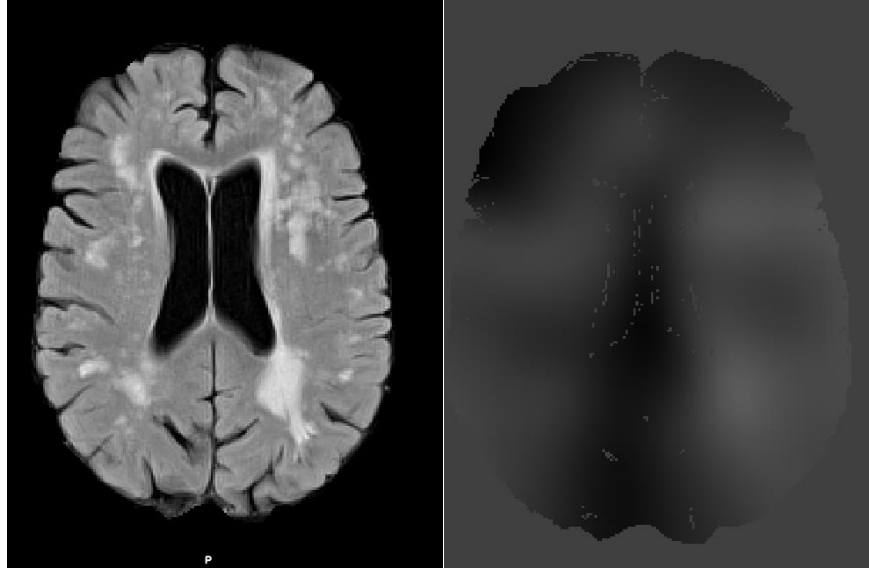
Original FLAIR image (left panel) later BF corrected using FAST (central panel). The outline of the magnetic field inhomogeneities is also displayed (right panel).
